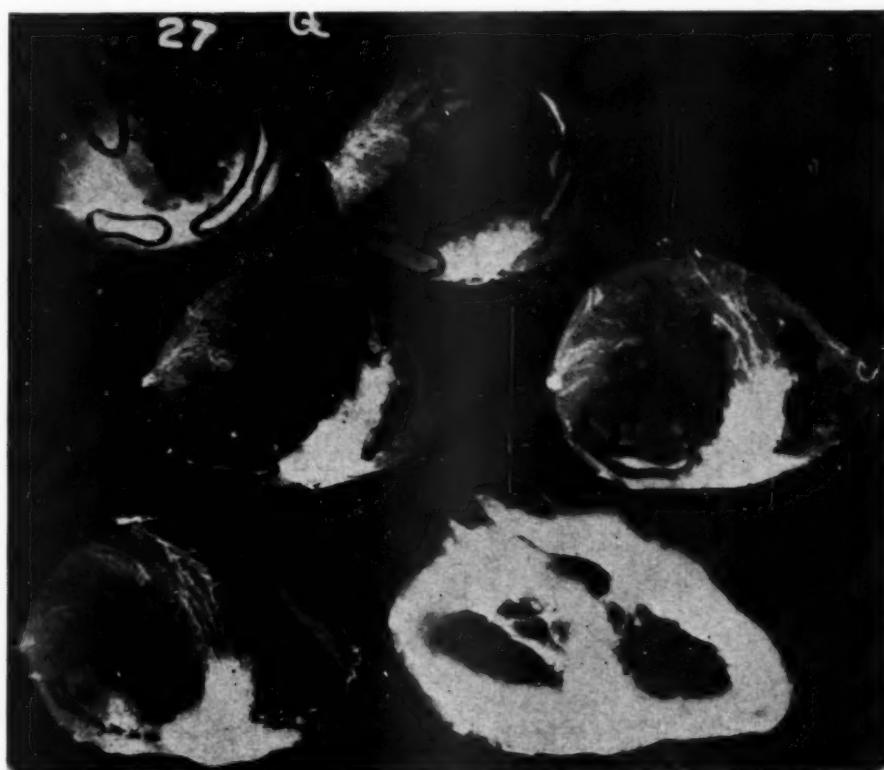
Roentgenogram of injected heart in Case 56, showing anteroposterior infarction and anteroapical aneurysm.
